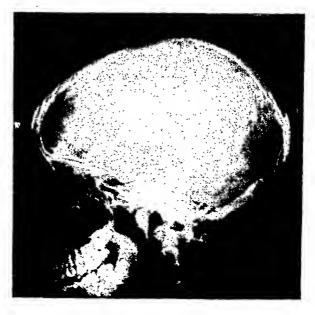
Case 11. Lateral roentgenogram of the skull.
